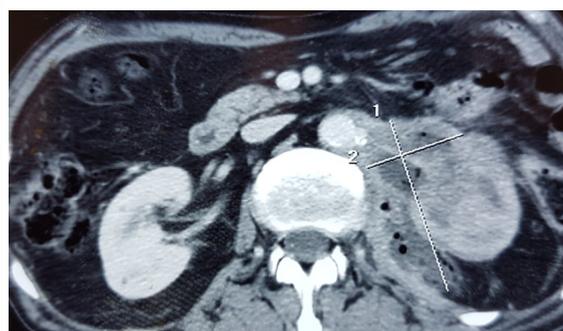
Axial Abdominal Enhanced CT Scan Showing Perinephric Abscess Extending to the Psoas Major Muscle Containing Gas Bubbles.
